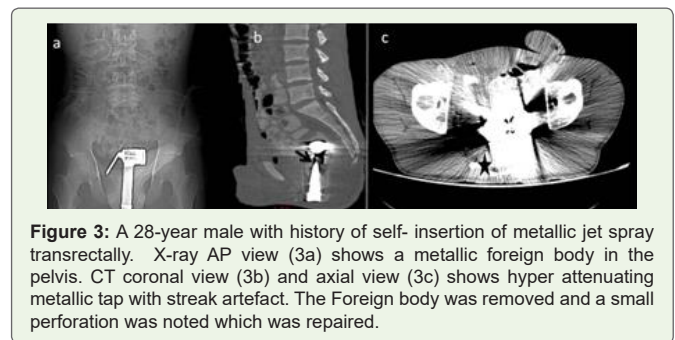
A 28-year male with history of self- insertion of metallic jet spray transrectally. X-ray AP view (3a) shows a metallic foreign body in the pelvis. CT coronal view (3b) and axial view (3c) shows hyperattenuating metallic tap with streak artefact. The Foreign body was removed and a small perforation was noted which was repaired.
